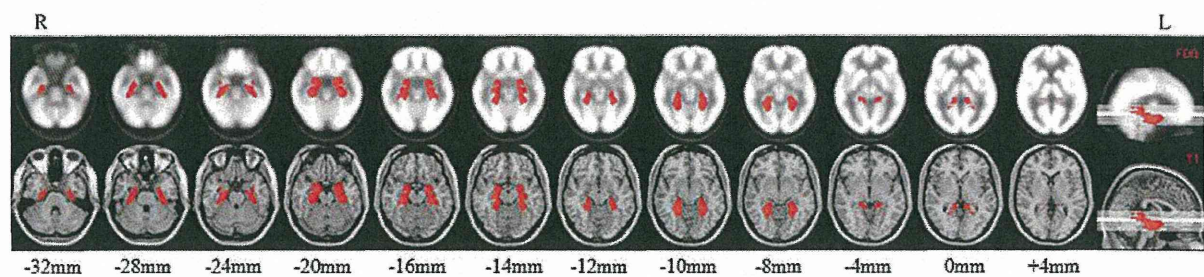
A set of right and left volumes-of-interest (VOIs) in the parahippocampal gyrus was selected for determination of the side with the epileptogenic zone in a patient with mesial temporal lobe epilepsy. Transaxial and sagittal sections on the *upper row* indicate VOIs (*red regions*) on our in-house FDG template. The *lower images*
